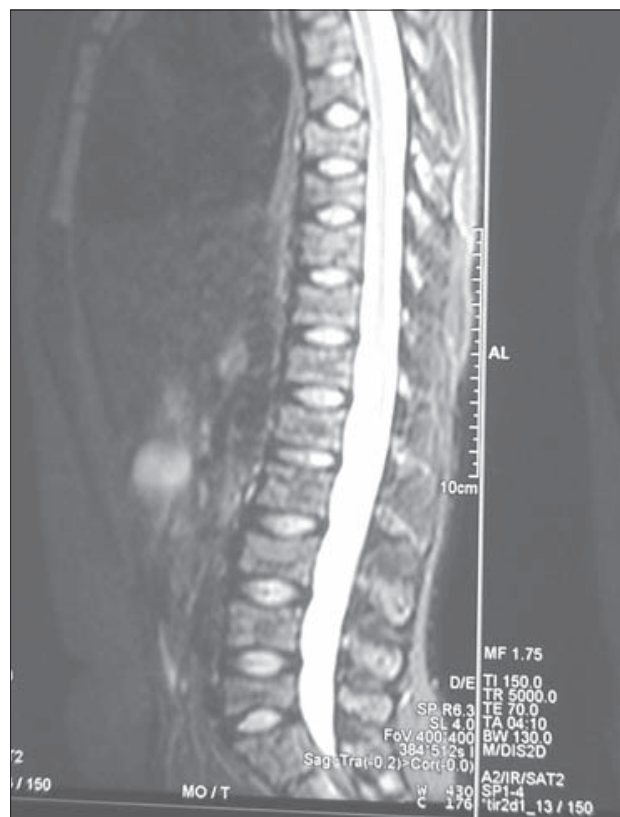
MRI shows compression fractures of vertebral bodies Th7, Th8, Th9, Th12 and L2, L4, L5.
